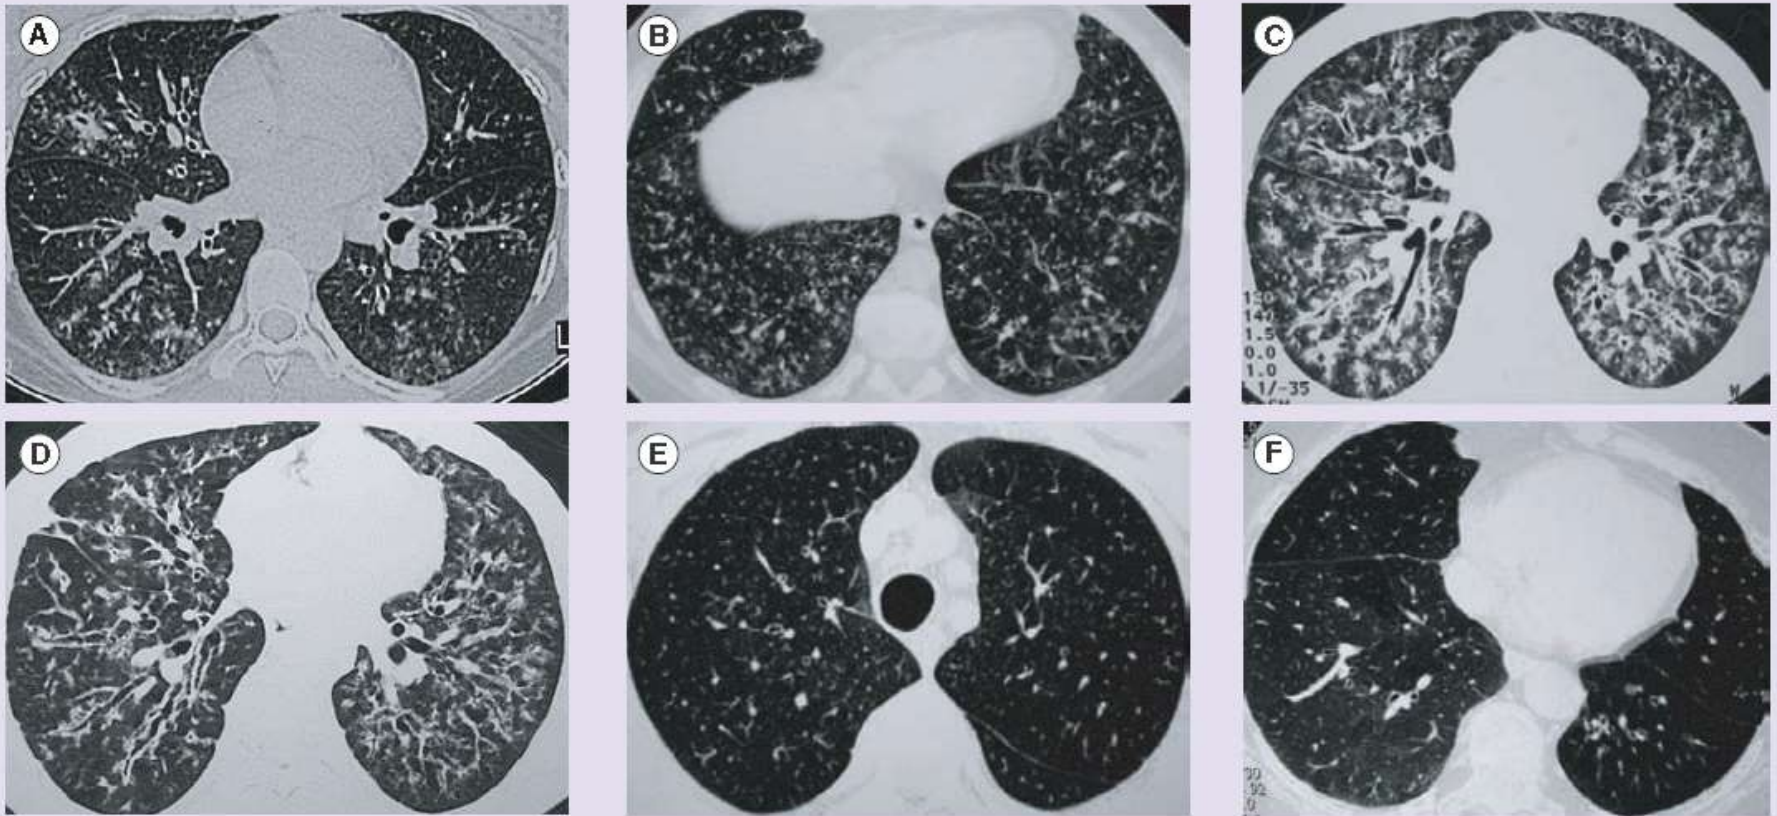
High-resolution computed tomography pictures of various forms of bronchiolitis.
